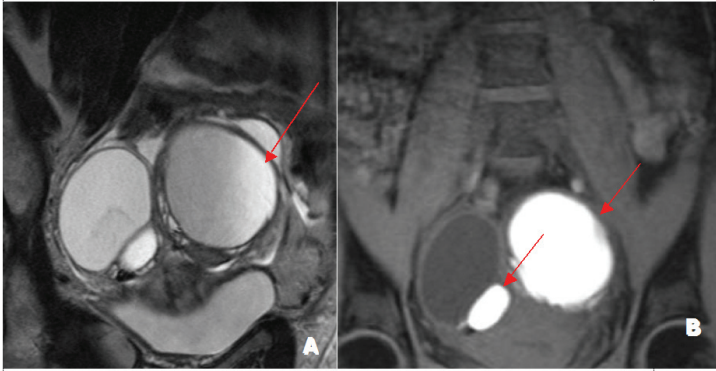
Endometriotic lesions appear mildly hypointense or hyperintense on T2-weighted images (A) and hyperintense on T1-weighted images (arrows in B). Gradual variation of signal intensity on T2-weighted images has been described as “shading” sign and is due to chronic bleeding with accumulation of high concentration of iron and protein in endometriomas (arrows in A).
